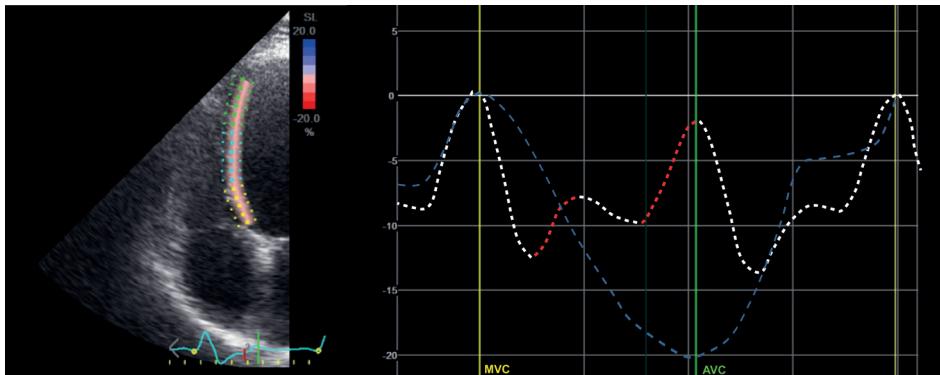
Myocardial speckle tracking strain curves of the interventricular septum. Echocardiographic image of the left ventricular septal wall (left) with tracing of the interventricular septum. Generated strain curves (right) derived with dedicated speckle tracking echocardiography software. Systole is occurring between MVC (mitral valve closing) and AVC (aortic valve opening) and diastole after AVC. Myocardial contraction results in negative strain values (dotted lines going down), while stretching is reflected by positive strain (lines going up) Systolic rebound stretch of the septum (SRS_{sept}) (in red) is defined as septal stretching after initial shortening during systole. CRT aims to convert systolic stretching into shortening and hence create predominant shortening during systole and stretching in diastole (dotted blue curve, representing a normal septal strain pattern).
